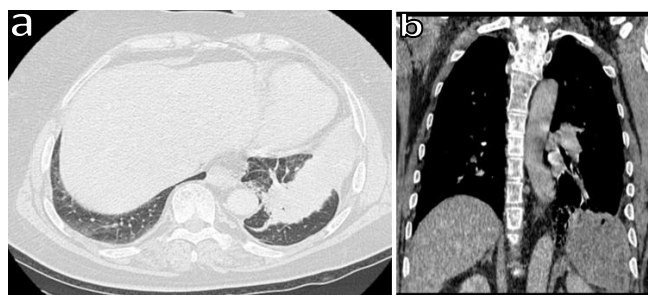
Thoracic computed tomography in parenchymal window (A) and mediastinal window (B) showing a well-defined tumor mass in the left lower lobe with clear margins against the lung parenchyma, suggesting a pleural origin
